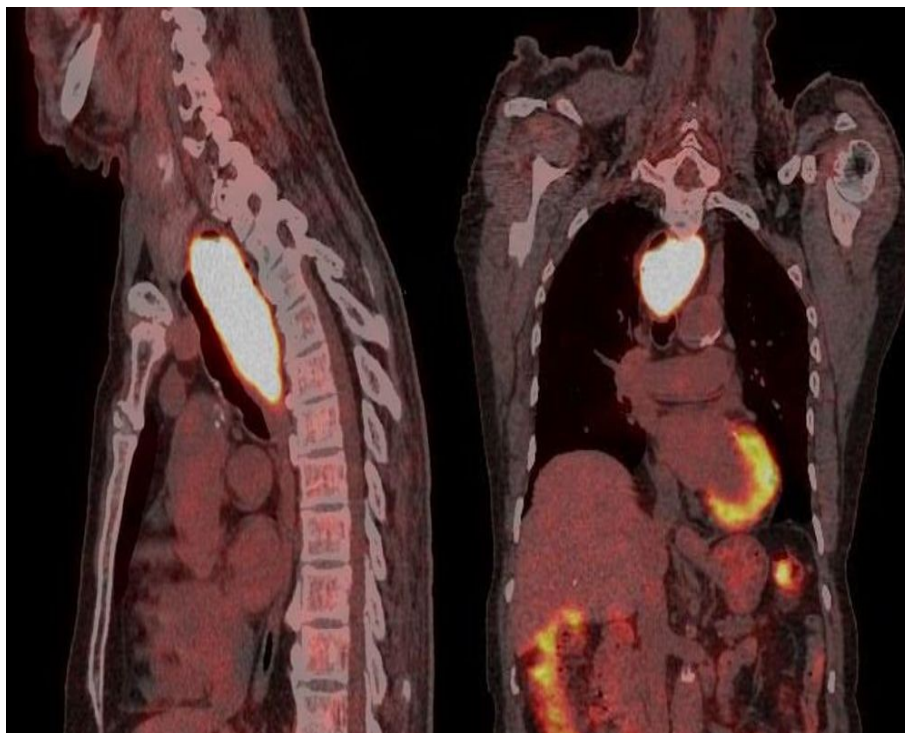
PET CT image showing FDG avid lesion in proximal esophagus.
